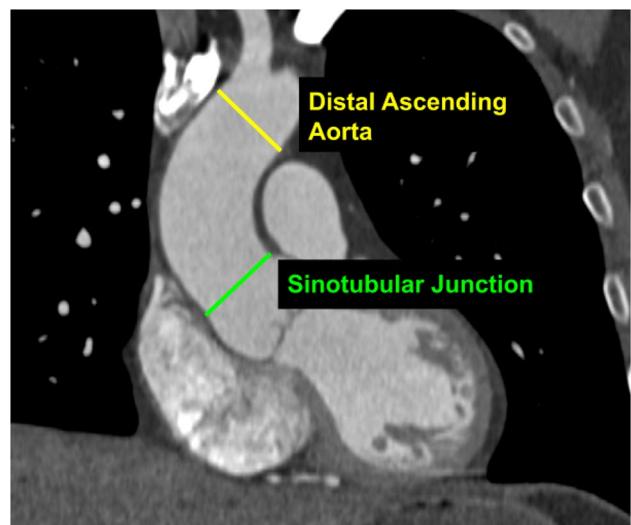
Coronal CTA slice showing positions of sinotubular junction and distal ascending aorta
